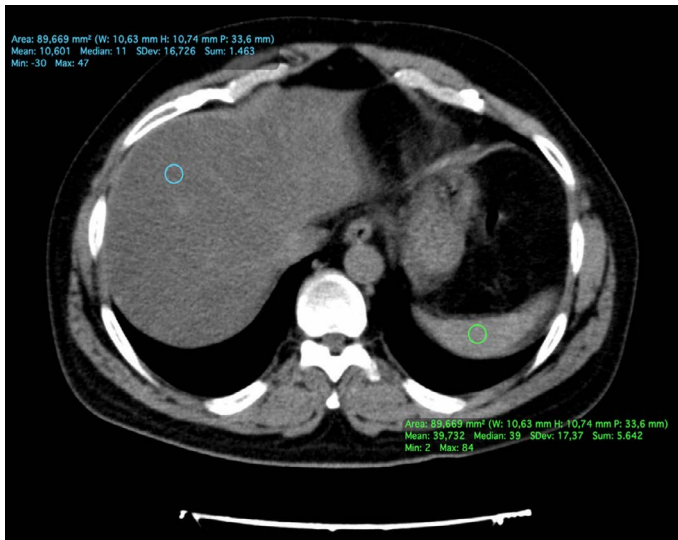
Axial non-contrast-enhanced CT slices show diffusely decreased parenchymal attenuation (low hepatic HU values compared to the spleen)
